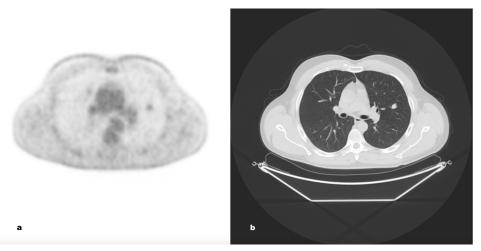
Axial thin-section 18F-FDG PET/CT (1a: PET image; 1b: CT lung window shows a nodular lesion measuring up to 11 mm in the lingular region demonstrating a low and not significant uptake of 18F-FDG. (SUVmax 1.1)
